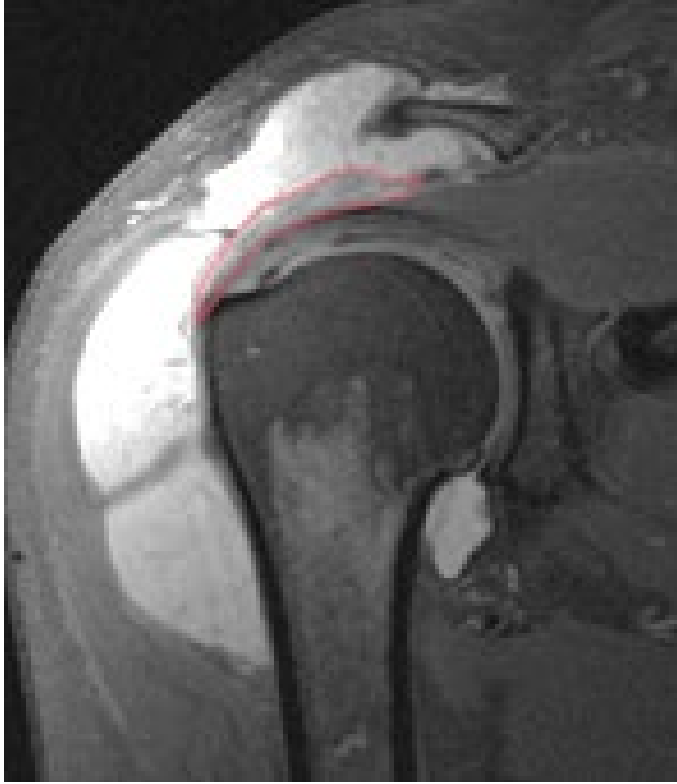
MRI of a patient post RCR with BDS augmentation. Imaging demonstrating markedly reactive subacromial-subdeltoid bursitis. The patient underwent subsequent bursectomy.
